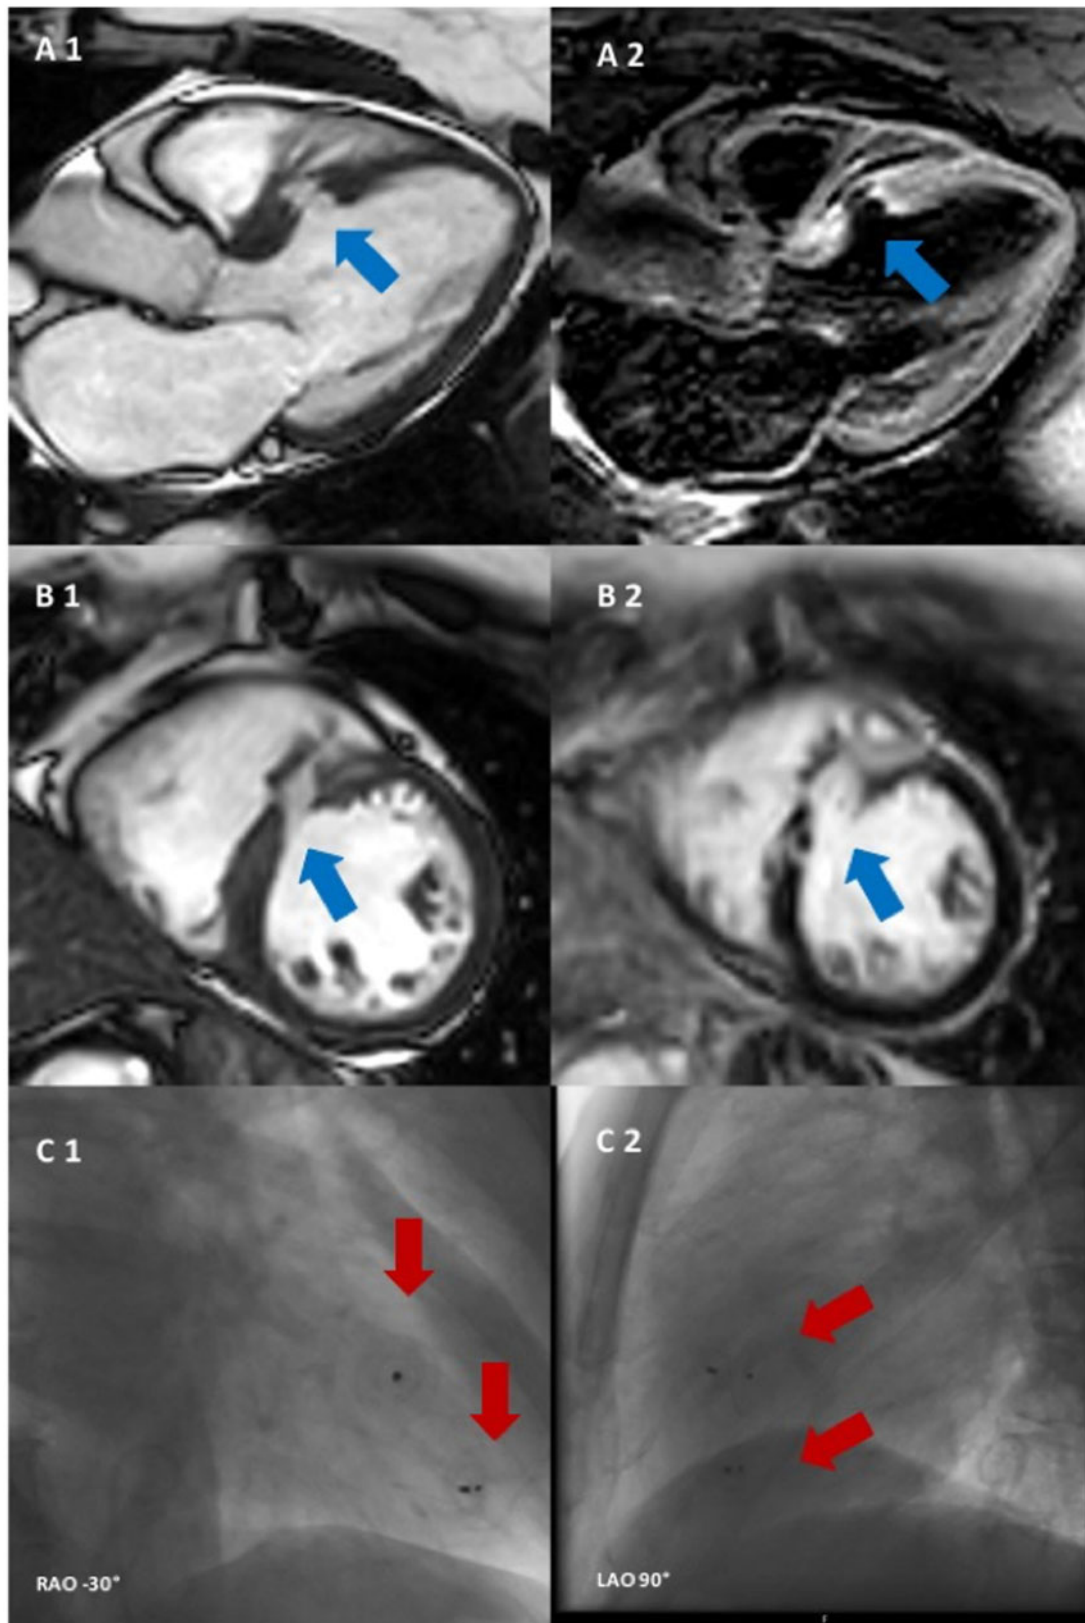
Cardiovascular magnetic resonance imaging (A, three-chamber geometry; B, short-axis geometry); blue arrows indicate ventricular septal defect location. Cardiovascular magnetic resonance demonstrated a 10 mm ventricular septal defect in the anteroseptal (basal) region (A1, cine still frame; A2, T2-weighted blackblood turbo-spin echo with ventricular septal defect surrounded by brightly appearing, oedematous myocardial tissue). Conventional X-ray fluoroscopy for demonstration of final occluder device position (red arrows): C1, right anterior oblique projection; C2, left anterior oblique projection.
